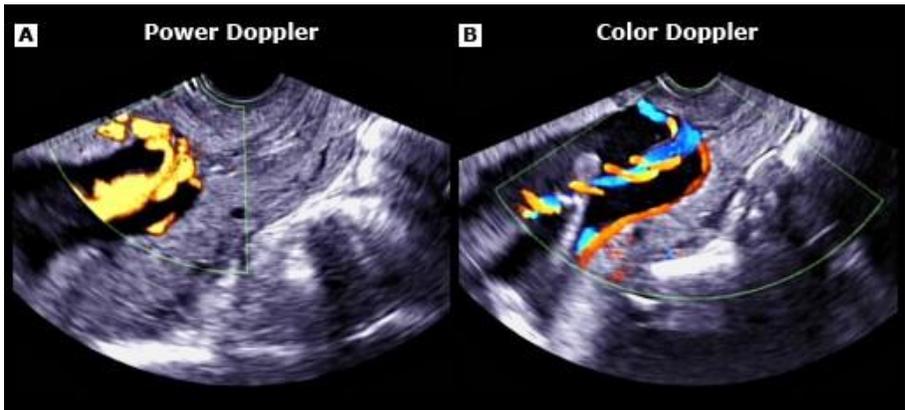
Succenturiate lobe placenta complicated by vasa previa on transvaginal ultrasonography
